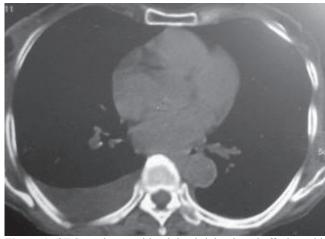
CT Scan thorax with minimal right pleural effusion with no mass
